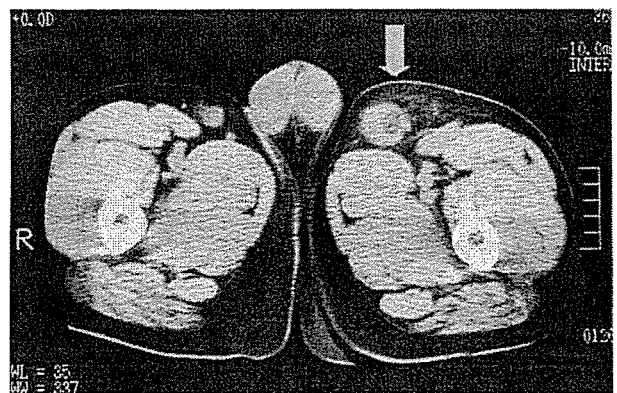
The computed-tomography X-ray film shows 30×40 mm of lymphadenopathy containing a 10×10 mm low-density area in the left inguinal region (arrow).
